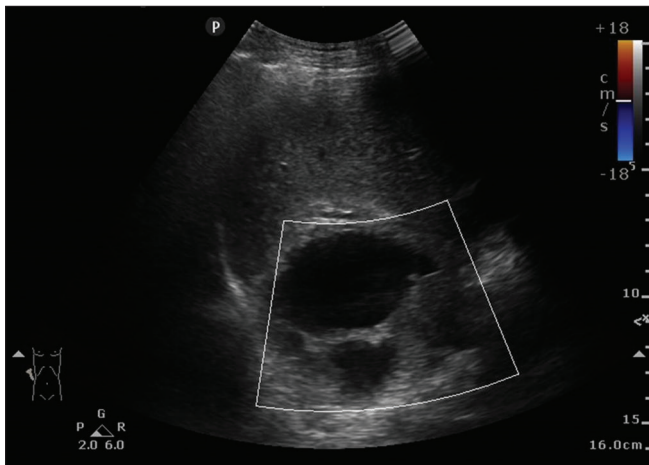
Point-of-care ultrasound image of color flow showing the mass without obvious vascular flow
